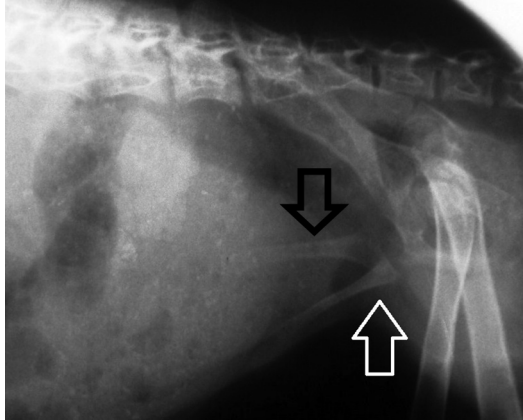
Radiograph shows marsupial bones (*Black and white arrows*) in Virginia opossum.
